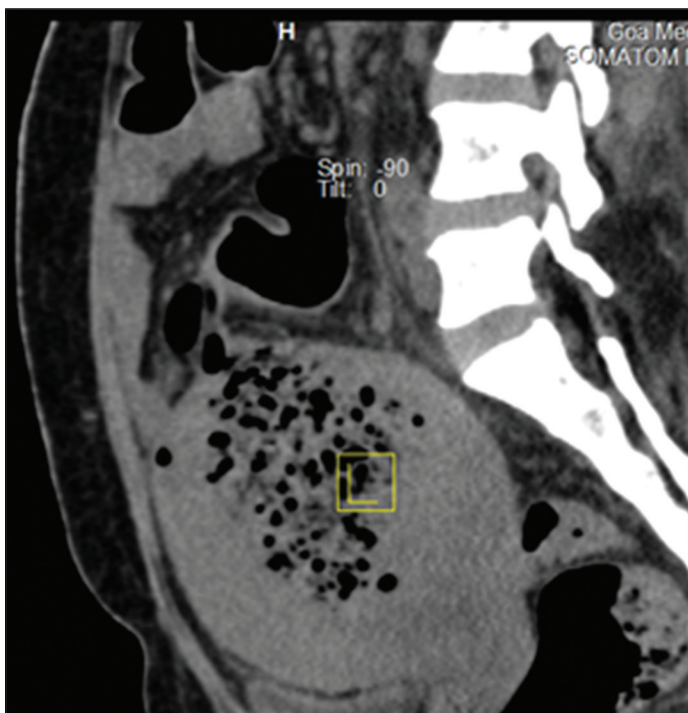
Contrast-enhanced computed tomography section showing uterine perforation with gas in the uterine cavity
